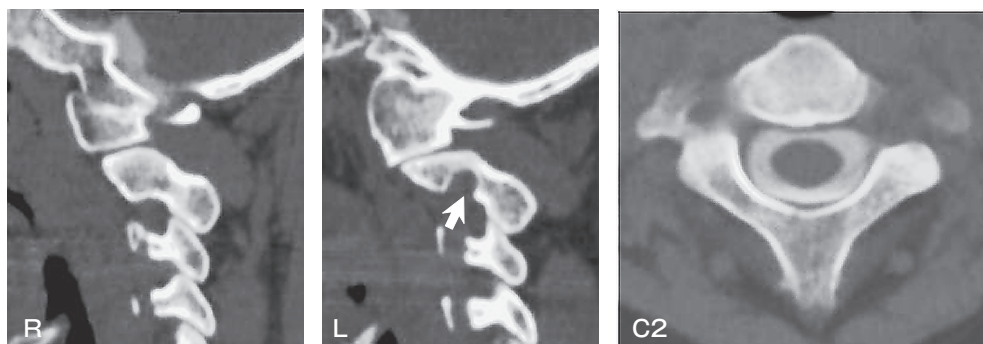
Preoperative CT myelography. Preoperative CT myelography showed a left side high-riding vertebral artery (white arrow).
